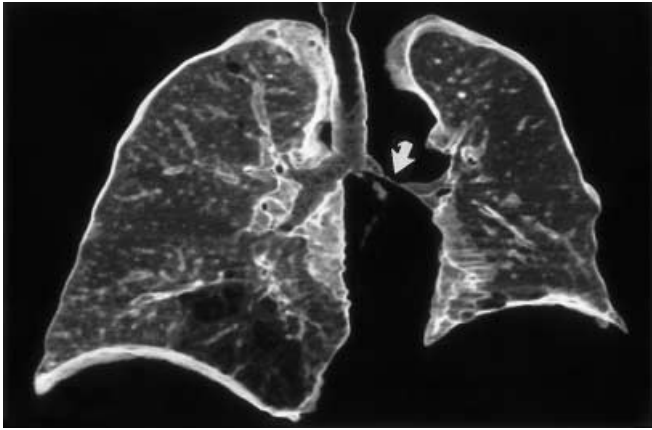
Volume rendering of the airways and lung parenchyma after multislice CT acquisition in a patient with Wegener's granulomatosis. A narrow and regular stenosis is visualized on the left main bronchus (*arrow*). Note the presence of emphysema in the right lower lobe
